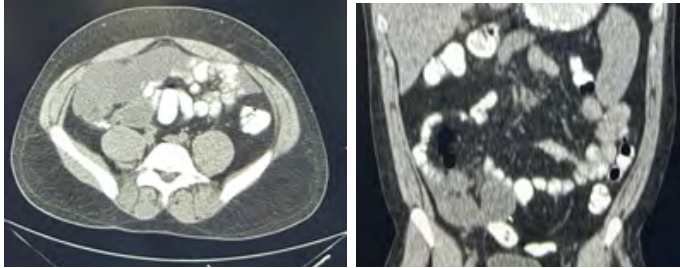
Case 3: CT showing vast quantity of muci in the abdominal cavity.
